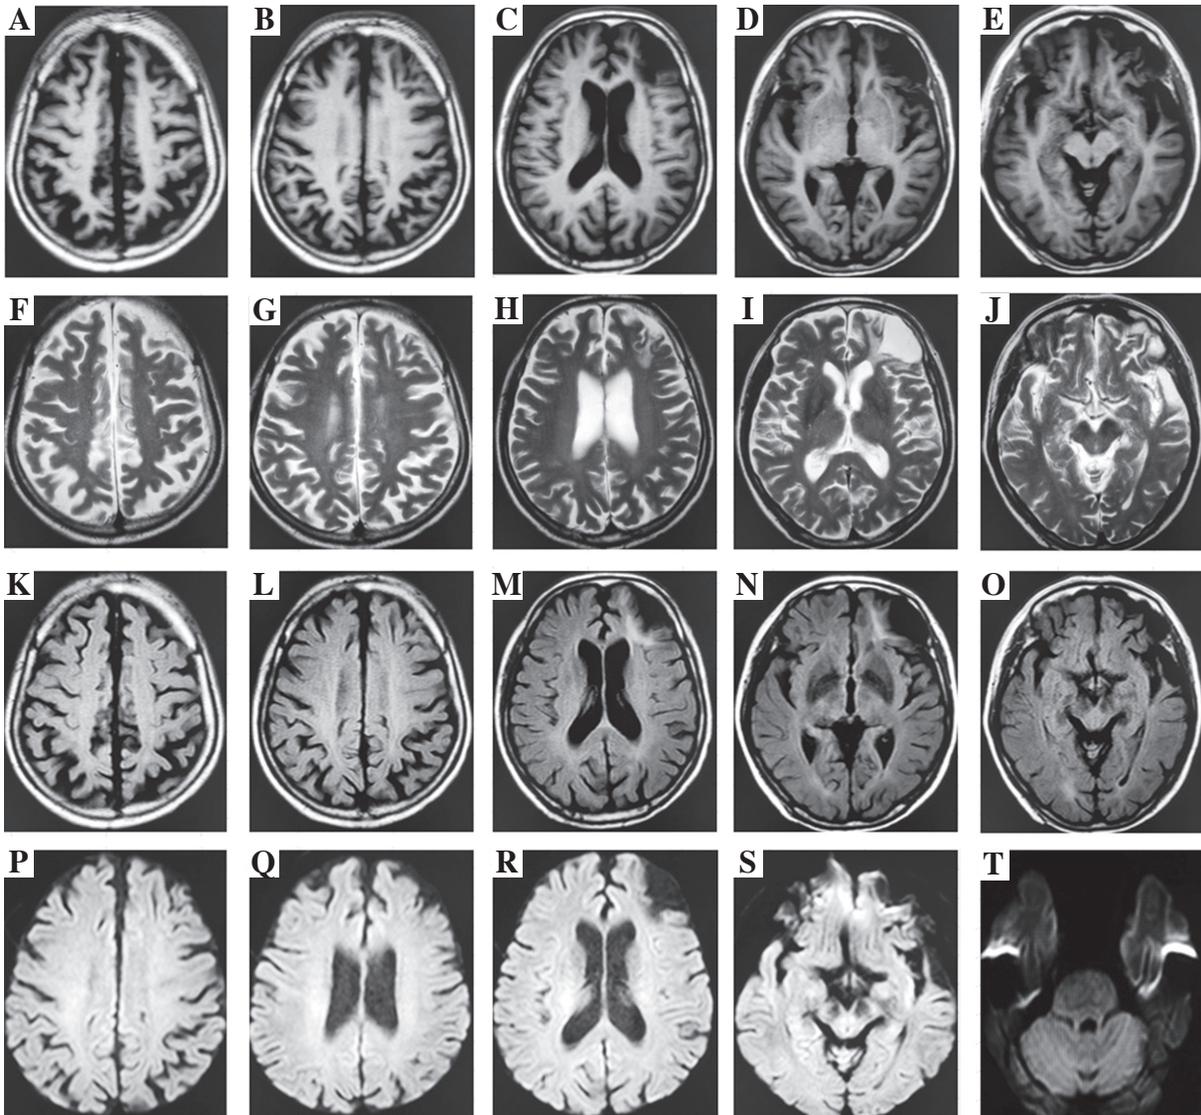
Non-contrast head MRI revealed abnormal signals in the left frontal and temporal lobes, as well as bilateral cerebellar hemispheres, with softening foci and adjacent gliosis. Imaging modalities included T1 (A-E), T2 (F-J), FLAIR (K-O), and DWI (P-T)
